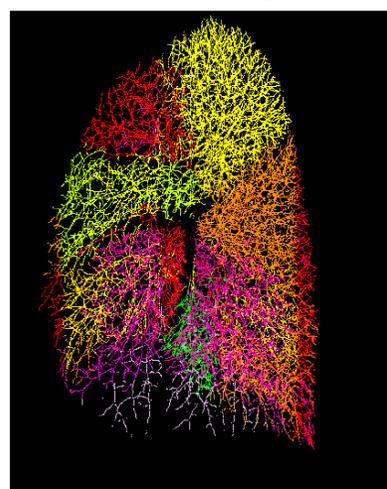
Example of 3D vasculature mask in right lung derived from CT [3], color-coded by lung segment.
